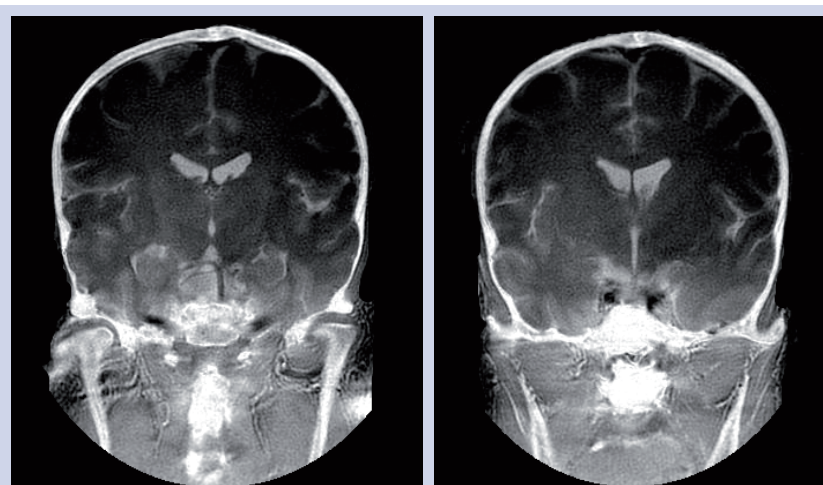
Ultrashort echo time MRI of the skull. The inner and outer tables of the skull are seen in a manner similar to x-ray CT with bone windows.
